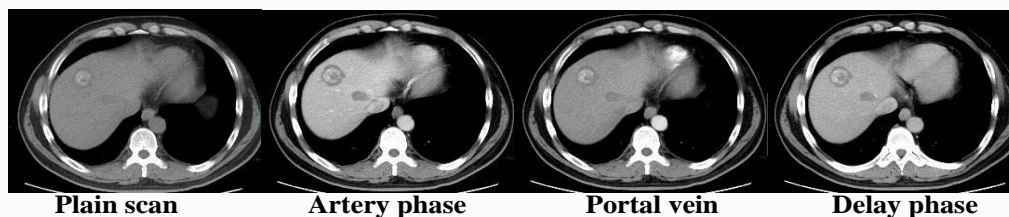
Follow up enhanced CT: no recurrence.
